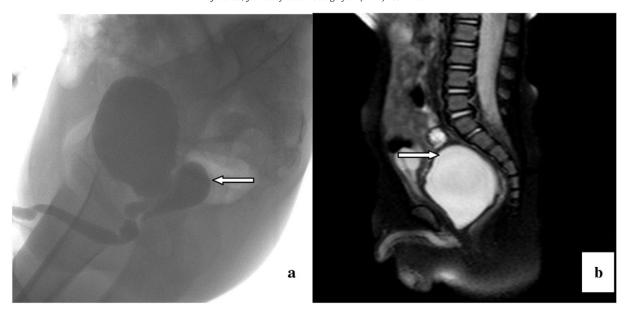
a VCUG showing a PU (white arrow) behind the bladder in patient no. 3. The lesion communicated with the posterior urethra. b MRI showing a large PU (black arrow) behind the bladder in patient no. 5 (white arrow, catheter sacculus).
